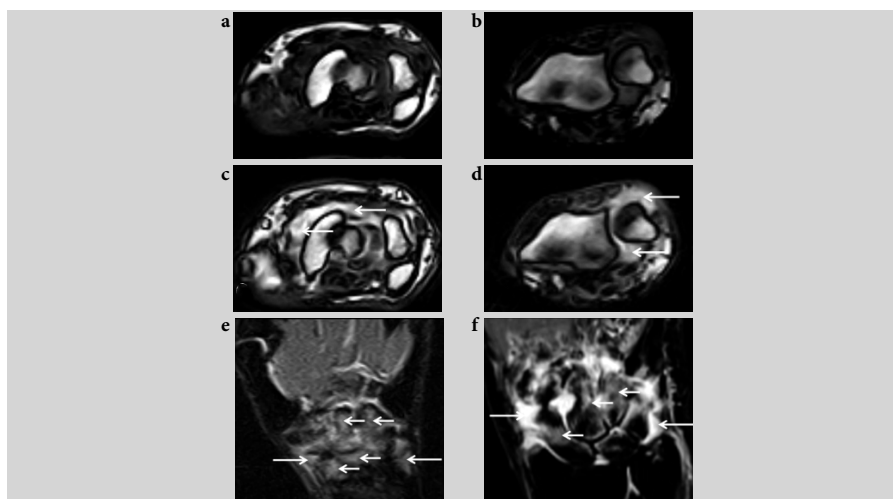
Magnetic resonance imaging (MRI) of wrists in patients with clinical remission but not imaging remission. (a–d): Axial T1-weighted MRI before (a–b) and after (c–d) intravenous contrast injection, in sections through the distal radius and ulna (a, c) and through the carpal bones (b, d). The patient is in clinical remission without clinical swelling or tenderness of the joint. Nevertheless, marked synovitis (arrows) is seen; (e) Coronal short tau inversion recovery (STIR) image of another patient in clinical remission, showing synovitis (long arrows) and bone edema (short arrows); (f) Coronal STIR image of another patient with rheumatoid arthritis, showing synovitis (long arrows) and bone edema (short arrows). Images a–e are courtesy of F. Gandjbakhch, Paris, France.
